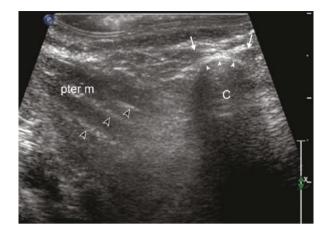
Sagittal sonographic image in a 35-year-old male volunteer asymptomatic for temporomandibular joint pain and dysfunction shows an anatomic overview. The condyle (C) is vertically oriented and hypoechoic (dark). The arc-shaped condylar surface, or "cap," is hyperechoic (small arrowheads), typical for subcondylar bone. The disc (arrows) is above the condylar cap, is hypoechoic, and is in a normal anatomic position in association with slight anterior condylar translation. The pterygoid muscles (pter m) are noted to the left (anterior), with hypoechoic muscle bundles separated by hyperechoic (large arrow heads) fat and fascial planes
